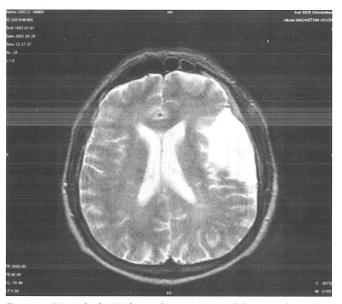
T2-weighted MRI showing hyperintense signal changes in the centrum semiovale.
